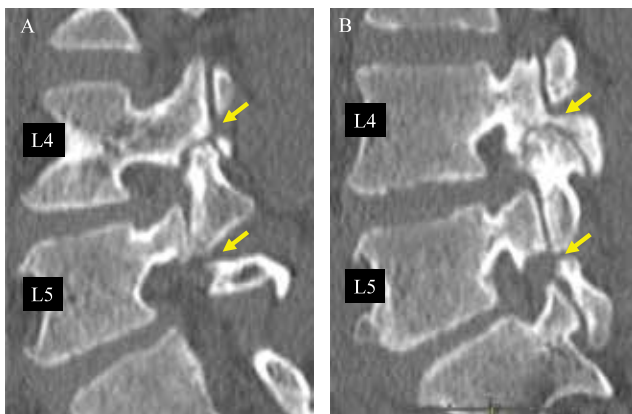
Preoperative right para-sagittal (A) and left para-sagittal (B) computed tomography scans showing pseudoarthrosis of the pars interarticularis bilaterally at L4 and L5.
